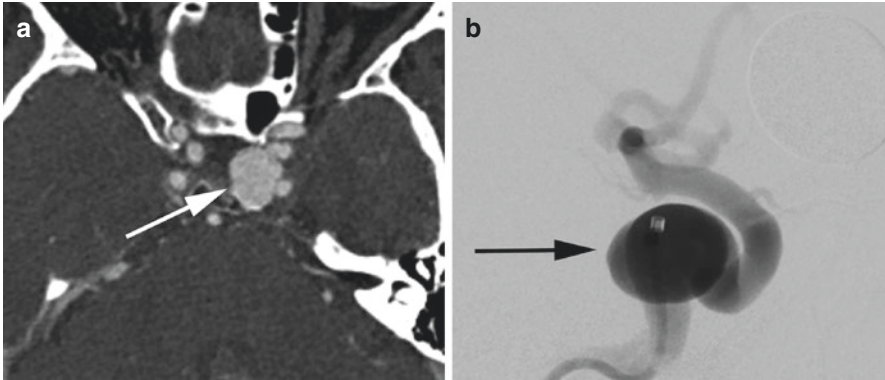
Cavernous internal carotid artery aneurysm. Patient with a large cavernous ICA aneurysm. CTA (a) and DSA (b) show the large saccular aneurysm involving the cavernous ICA segment (arrows)
